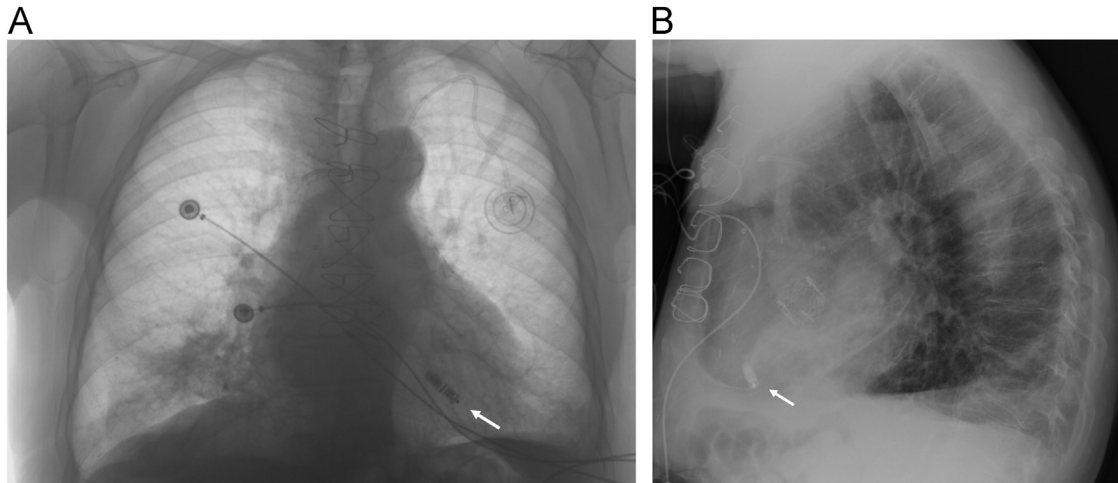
(A) Posteroanterior chest radiograph demonstrating a Medtronic Micra device (solid arrow). (B) Lateral chest radiograph demonstrating a Medtronic Micra device (solid arrow) at the apex.
